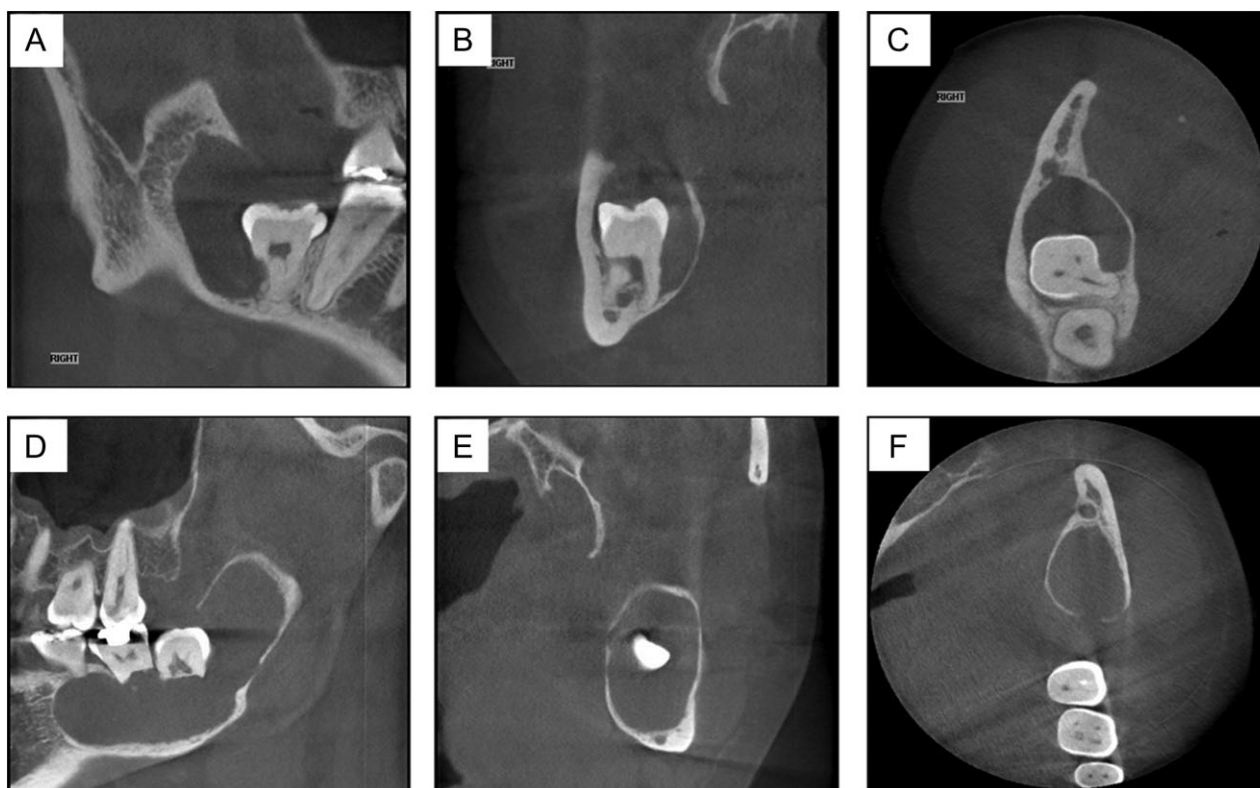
Representative cone beam computed tomographic slides demonstrating bilateral mandibular intra-osseous cystic lesions and associated root resorption. (A) Sagittal view of the right mandibular angle. (B) Coronal cut at the level of the lower right wisdom tooth. (C) Axial cut of the right mandibular angle region. (D) Left mandibular angle sagittal cut. (E) Coronal cut of the left mandibular angle region. (F) Axial cut of the left mandibular body and angle region, showing the cystic lesion in front of the inferior dental canal.
